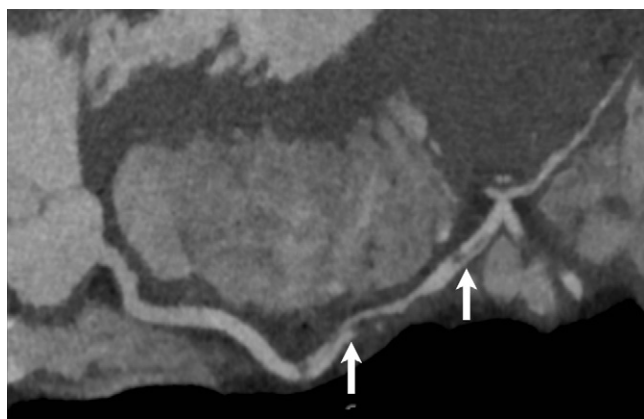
Curved planar reformatted coronary CT angiography image in a 29-year-old man with chest pain and elevated troponin level shows right coronary artery intimal disruption and dissection flap (arrows).
